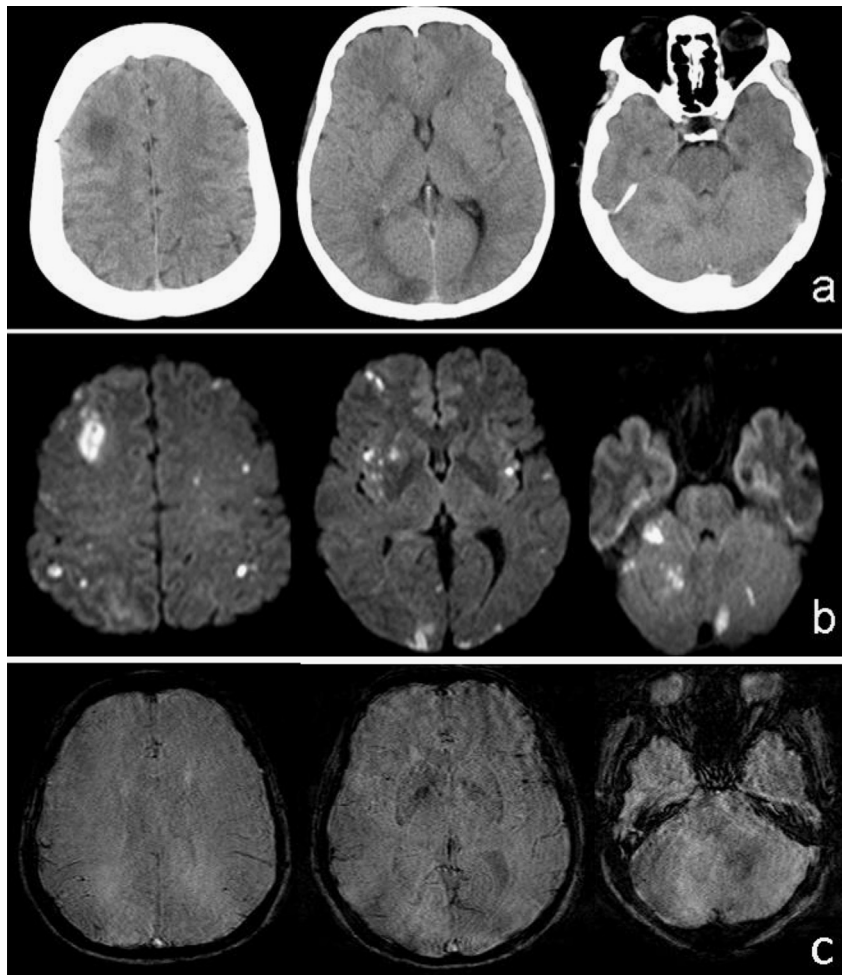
CT on 2nd day of admission showed multiple patchy low-density areas on right frontal, parietal, occipital lobes and bilateral cerebella (1a). MRI on the same day showed multiple patchy limited diffusion lesions on bilateral frontal, parietal, and occipital lobes and bilateral cerebella on DWI (1b). No abnormality was found on SWI (1c). Findings on both CT and MRI support that the lesion was infectious but the etiology needs to be further confirmed.
